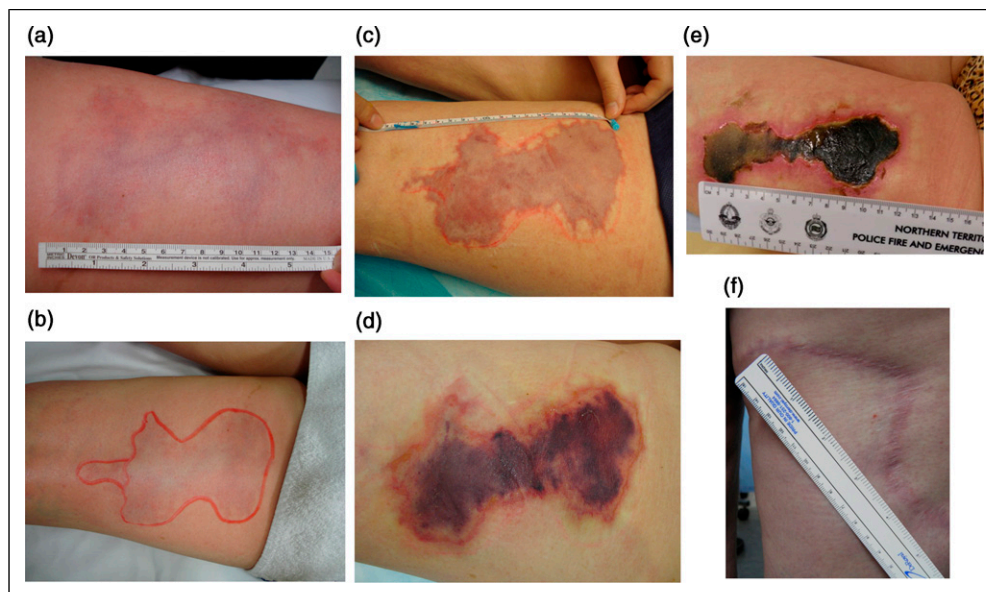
Intra-arteriolar Injection of polidocanol (POL). Clinical evolution of skin necrosis localised to the right posterior thigh following injection of polidocanol 1.5% liquid under ultrasound guidance to treat the thigh extension of the small saphenous vein (vein of Giacomini). No arterial signal was detected on duplex at the time of injection. An inadvertent sclerosant injection into the small intra-fascial arteriole accompanying the vein of Giacomini can be presumed. No pain was experienced by the patient at the time of injection. (A) Within 10 minutes- retiform purpura. A violaceous and localised patch of retiform (mottled) purpura was noted after the initial pallor. (B) Demarcation of retiform purpura marked at 10 min of the incident. The mottled retiform morphology signifies compromised skin perfusion. (C) Day 4- Stellate purpura (Day 4). Dusky grey cyanotic plaque exhibiting dendritic edges. These skin changes signify impending necrosis. (D) Stellate purpura (Day 9). Demarcated area of intense purpura. (E) Stellate necrosis (Week 6). Skin necrosis developed despite treatment with oral prednisone and subcutaneous enoxaparin. (F) Week 12. Excision of the ulcer and flap repair was performed 7 weeks post event. The surgical scar (shown here) was further revised with subisions and vascular laser (photos courtesy of Dr Stefania Roberts, Australia).
